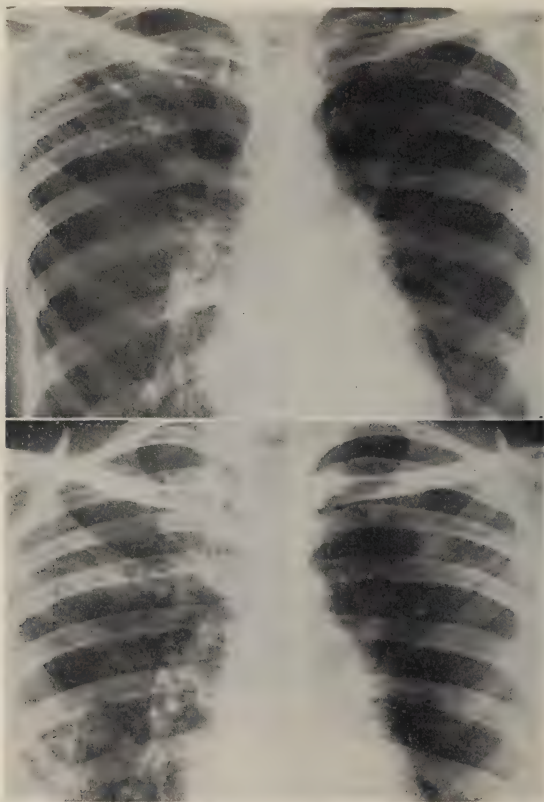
(Case 8). A (Top). Roentgenogram exhibiting linear fibrosis at the right apex above the clavicle in the first and second intercostal spaces, fan-shaped, radiating from the root.
